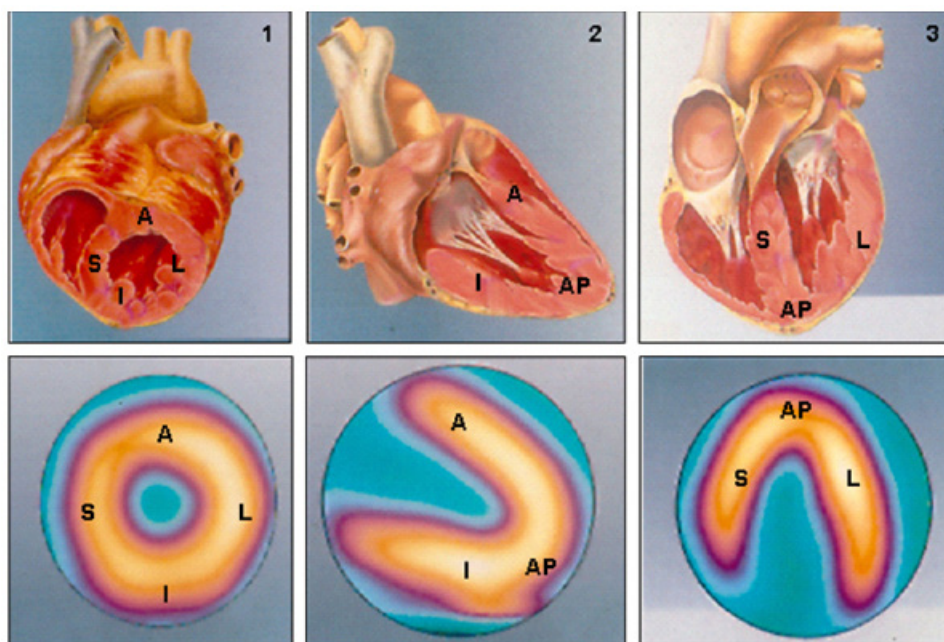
Two-dimensional reconstruction of scintigraphy images representing normal perfusion patterns (lower images), in line with minor axis (1), vertical long axis (2), and horizontal long axis (3) cross sections and their respective corresponding anatomical cross sections (upper images). A: anterior; AP: apical; I: inferior; L: lateral; S: septal. Adapted from Mastrocola LE.¹⁹⁵
